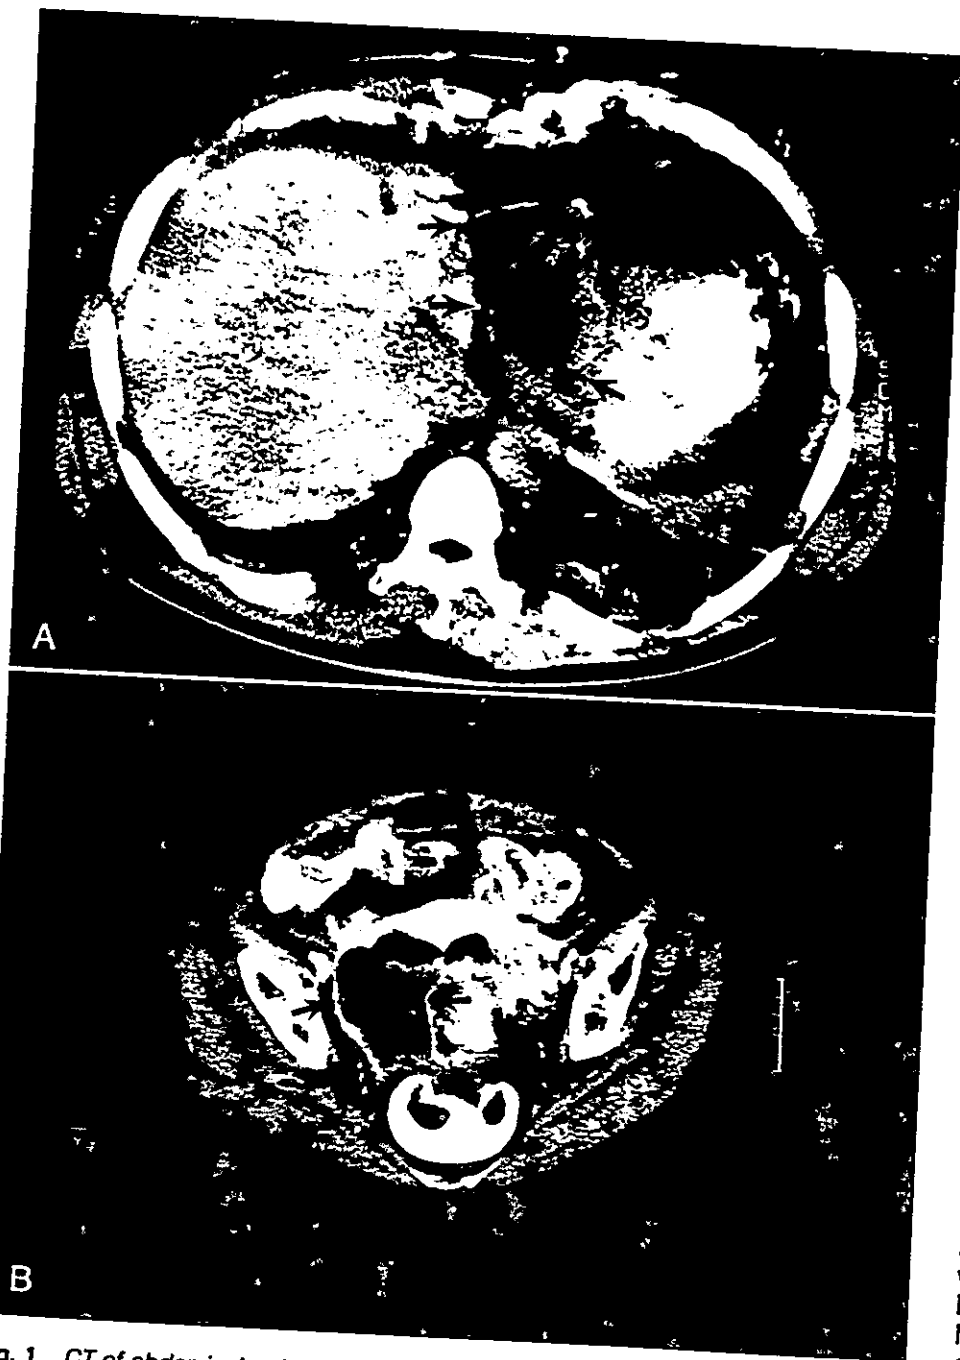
CT of abdominal-pelvic abscess. A, Axial scan obtained 5 days after partial resection of left lobe of liver for trauma demonstrates large collection of fluid with air-fluid level (arrows) between liver and lesser curvature of stomach. Stomach contains oral contrast medium. An abscess was surgically drained. B, Axial CT scan through pelvis obtained in patient with sepsis demonstrates large fluid and gas collection (arrows) to right of rectum. No contrast material is seen within collection. At surgery, collection proved to represent an abscess.
